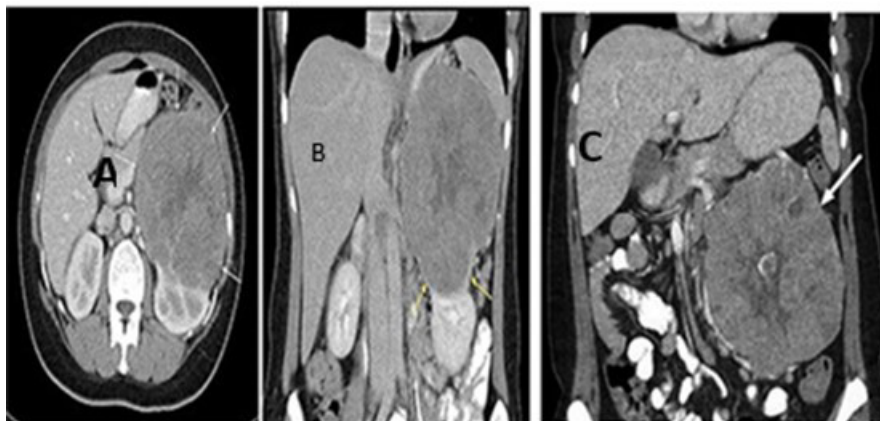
(A–C) Contrast-enhanced CT axial and coronal scans show a well-defined, large left renal mass with heterogeneous enhancement and areas of necrosis. The C-LEFT kidney shows a large, well-circumscribed solid tumor (arrow) with a hypoattenuating central stellate scar and internal calcification.
